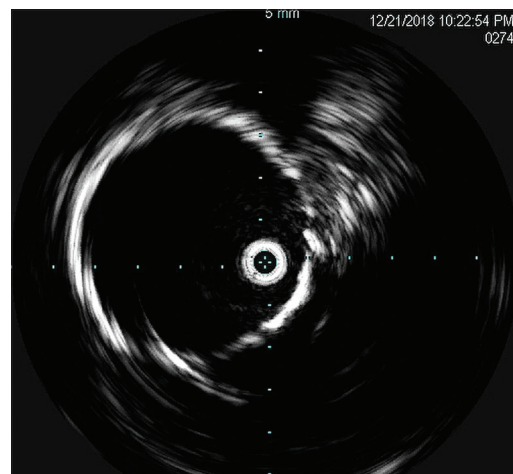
Intravascular ultrasound (IVUS), placed intra graft in the neo-descending aorta. Demonstrates adequate wall anatomy and normal luminal/tubular structure within the elephant trunk graft while moving IVUS probe distally
